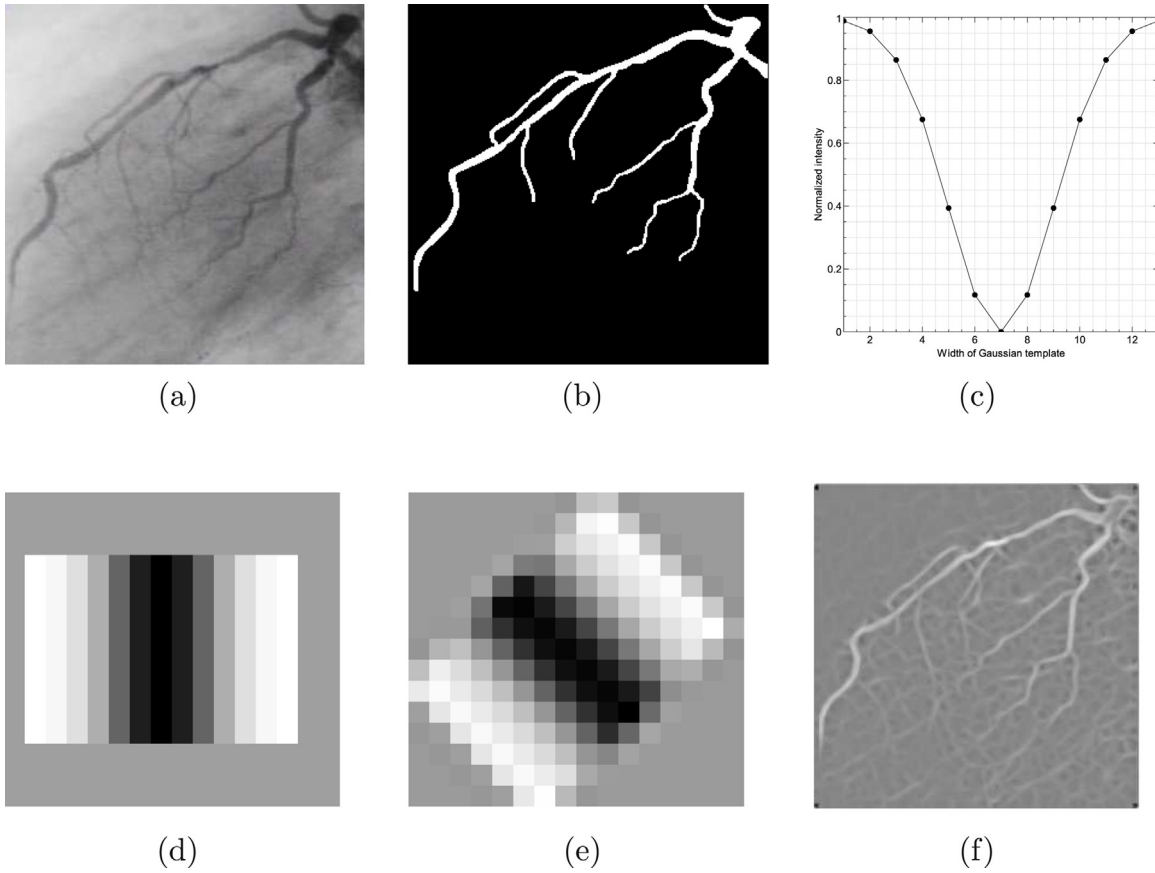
(a) Original X-ray coronary angiogram. (b) Ground-truth of angiogram in (a). (c) Gaussian kernel proposed by Chaudhuri et al. [15]. (d) Gaussian template with $\theta = 0^\circ$. (e) Gaussian template with $\theta = 45^\circ$. (f) Resulting enhanced image using the angiogram in (a) and the Gaussian kernel in (c).
